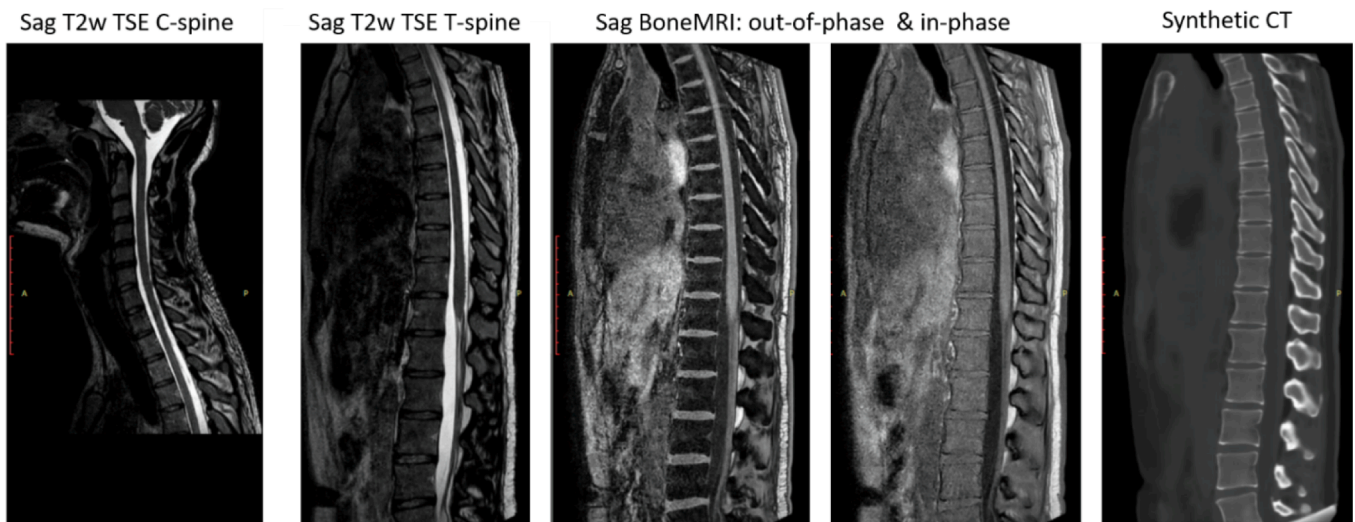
MR images acquired in one volunteer: 3D Sag T2w TSE of C-spine and T-spine, BoneMRI source out-of-phase and in-phase images and the reconstructed synthetic CT images.
